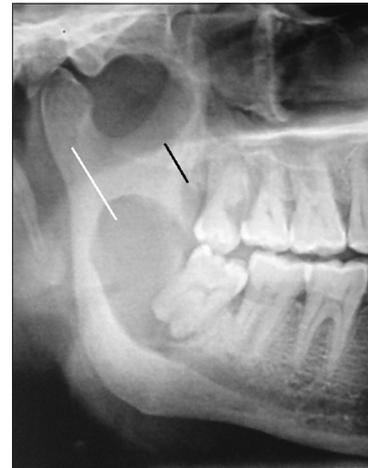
Panoramic radiograph showing a well-defined, flame-shaped radiolucency of different density is seen on the distal aspect of 48 (black arrow) and a well-defined, solitary, unilocular, oval radiolucency on the distal aspect of 48 (white arrow)
